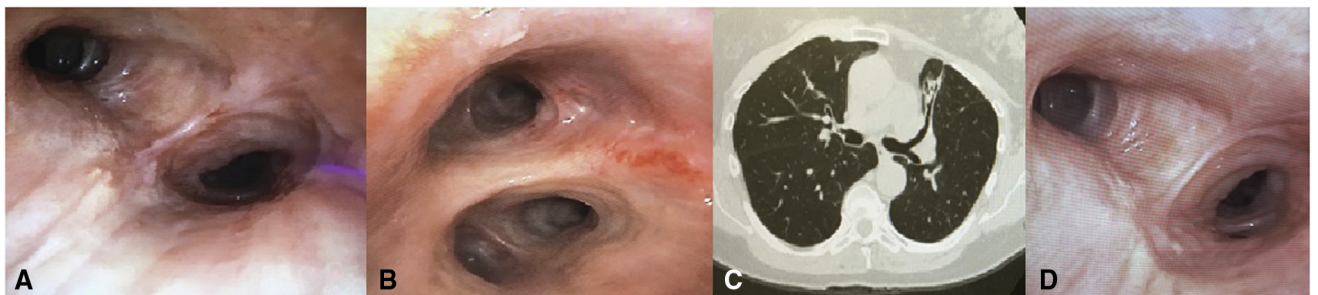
A, Bronchoscopy at 3 months demonstrating tumor clearance (patient 2). B, Bronchoscopy at 12 months demonstrating no tumor (patient 1). C, Computed tomography of the chest at 12 months demonstrating no disease (patient 1). D, Bronchoscopy at 36 months demonstrating no tumor (patient 2).
